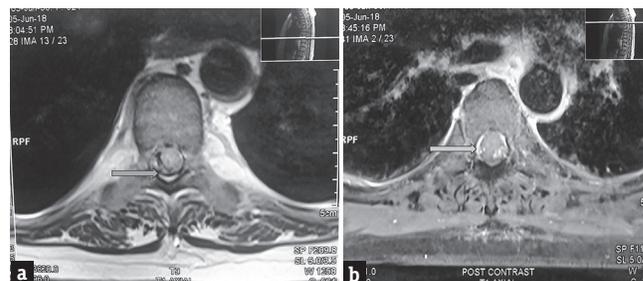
(a) Precontrast magnetic resonance imaging dorsal spine axial section showing area of hypointensity within the subdural space. (b) postcontrast images showing heterogenous enhancement within the subdural space on T1 axial sequence indicating hemorrhage/blood degradation products
